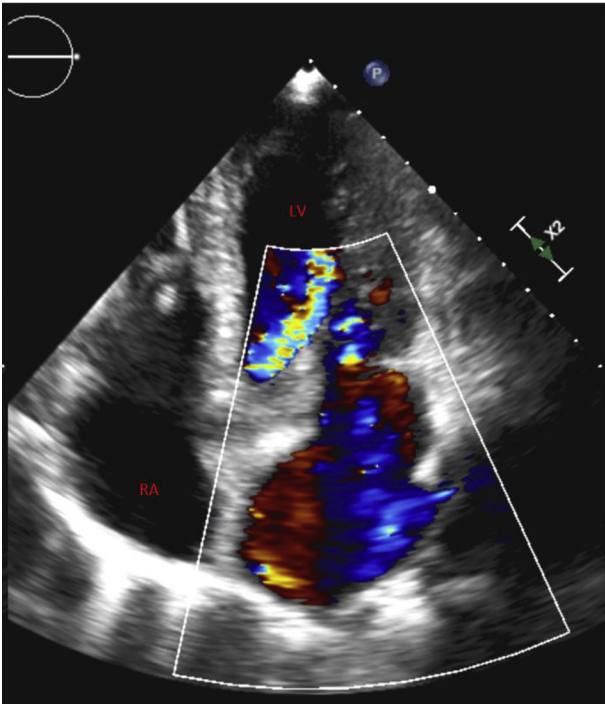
Four-chamber echocardiographic view with color Doppler indicating moderate aortic regurgitation and severe mitral regurgitation. LV, Left ventricle; RA, right atrium.
